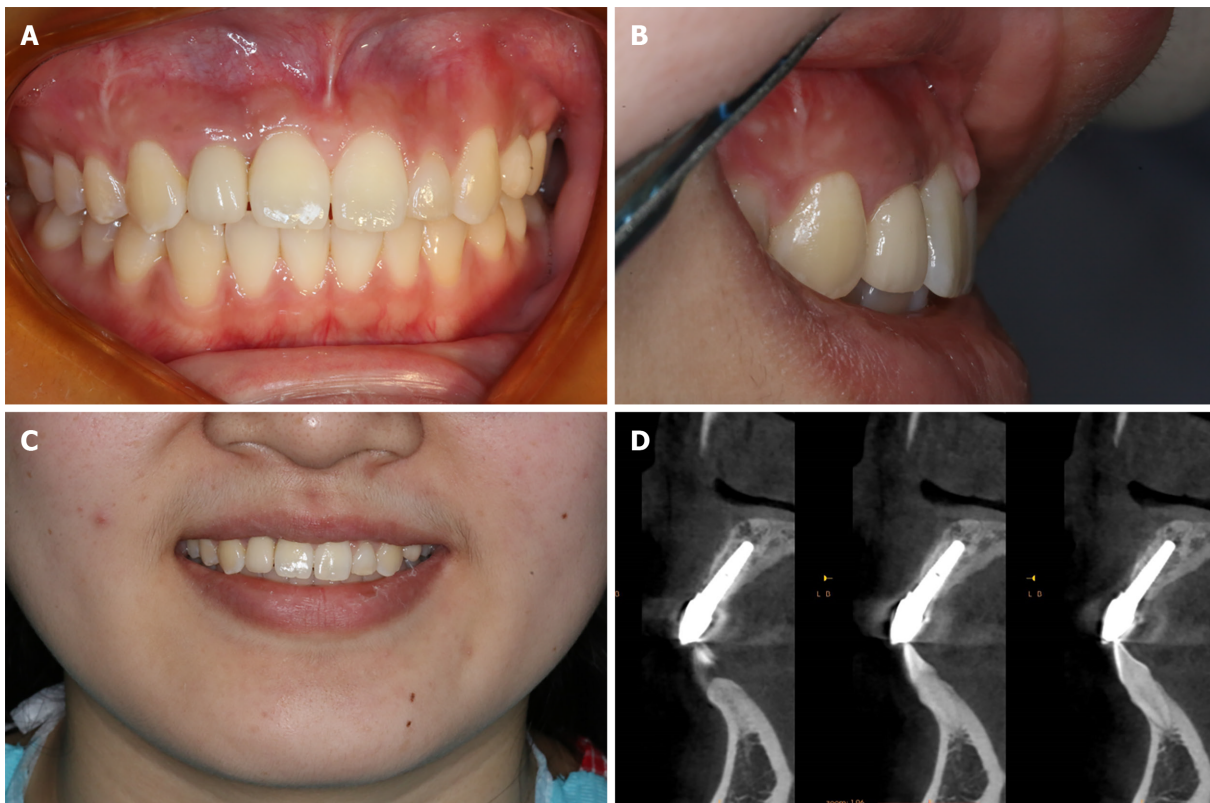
Assessments at 1 year after surgery. A-C: Intraoral condition; D: Cone-beam computed tomography image showing the stable bone around implant.
